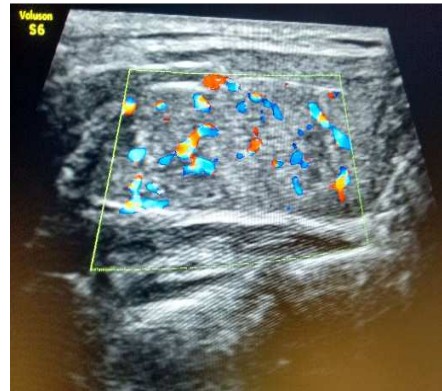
Thyroid scan and doppler showing thyromegaly and increased vascularity in the thyroid gland.
